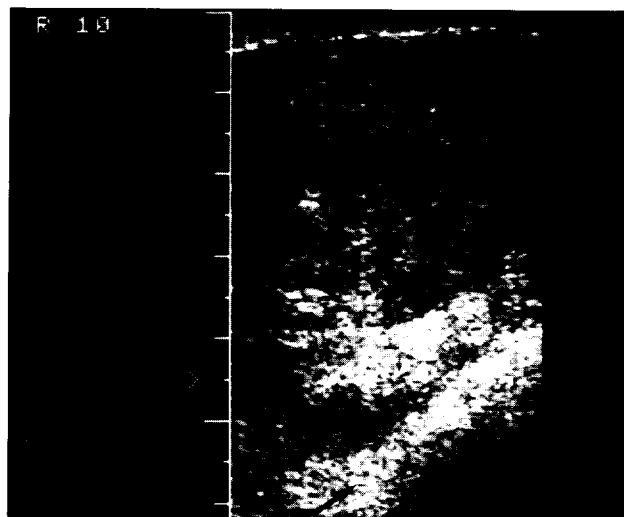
Ultrasound showing a well-circumscribed mass. The adjacent breast tissue is more echogenic
